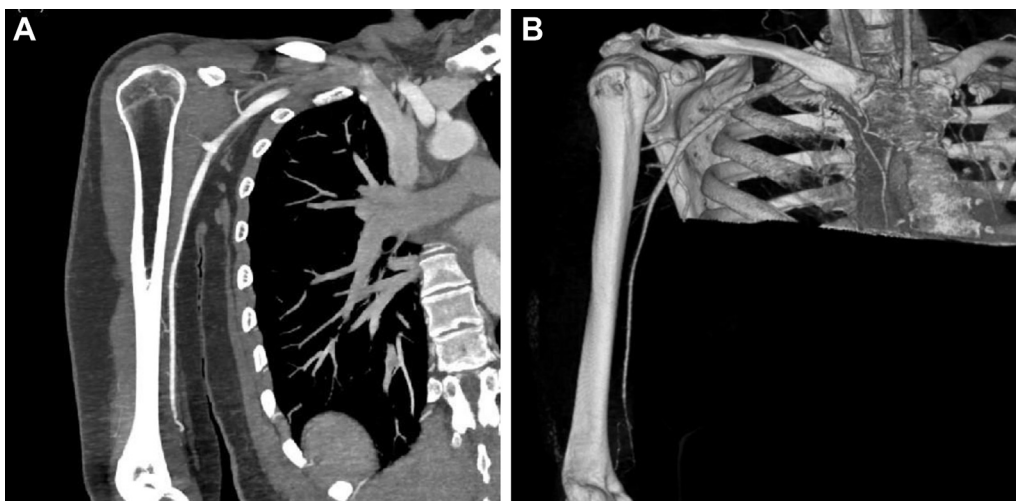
Occlusion of the right brachial artery on (A) computed tomography angiography and subsequent (B) three-dimensional reconstruction.
